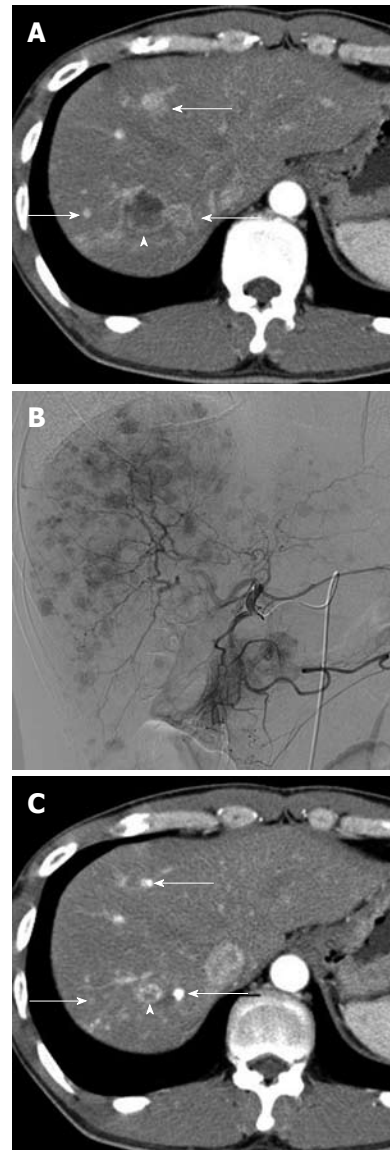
Images obtained in the case of a 38-year-old man with systemic chemotherapy-resistant multiple hepatic metastases from a pancreatic neuroendocrine tumor. A: Arterial phase image of contrast-enhanced computed tomography (CT) shows well-enhanced metastatic tumors (arrows) as well as a hypodense tumor due to cystic degeneration with marginal enhancement (arrowhead); B: A selective hepatic angiogram delineates innumerable hypervascular metastatic tumors throughout the liver; C: Arterial phase image of contrast-enhanced CT at 3 mo after chemoembolization with miriplatin-iodized oil suspension demonstrates a significant reduction in the size of all lesions, with compact accumulation of iodized oil in the hypervascular tumors (arrows). It should be noted that the tumor with cystic degeneration was also reduced in size (arrowhead).
